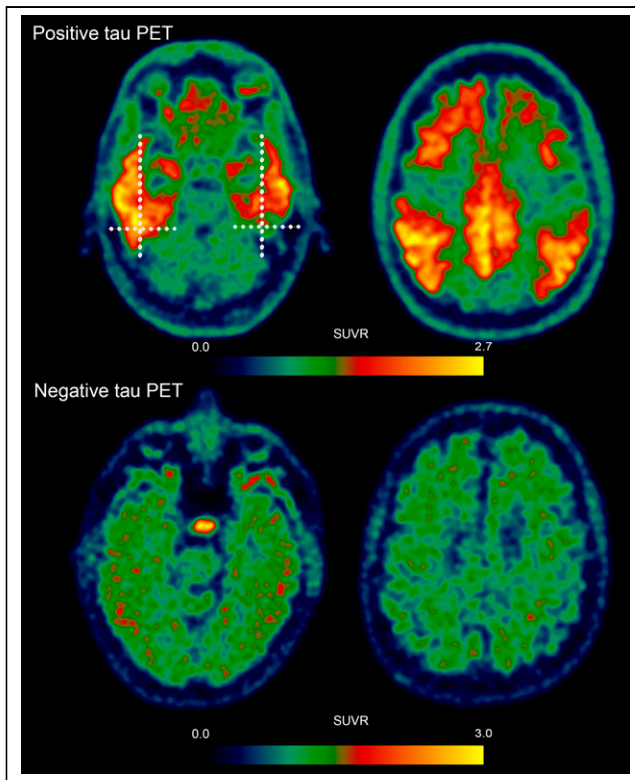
Tau PET with ^{18}F -florbetapir. (Top row) Positive tau PET with areas of abnormally increased (red and orange color overlay) uptake in lateral temporal, frontal, and parietal lobes, including precuneus and posterior cingulate. Temporal lobes are divided into quadrants (dotted lines). Only uptake in posterolateral quadrant of temporal lobe should be used to consider ^{18}F -florbetapir PET scan positive using visual interpretation. (Bottom row) Negative tau PET with no abnormally increased regions of uptake in cerebral hemispheres. SUVR = SUV ratio.
